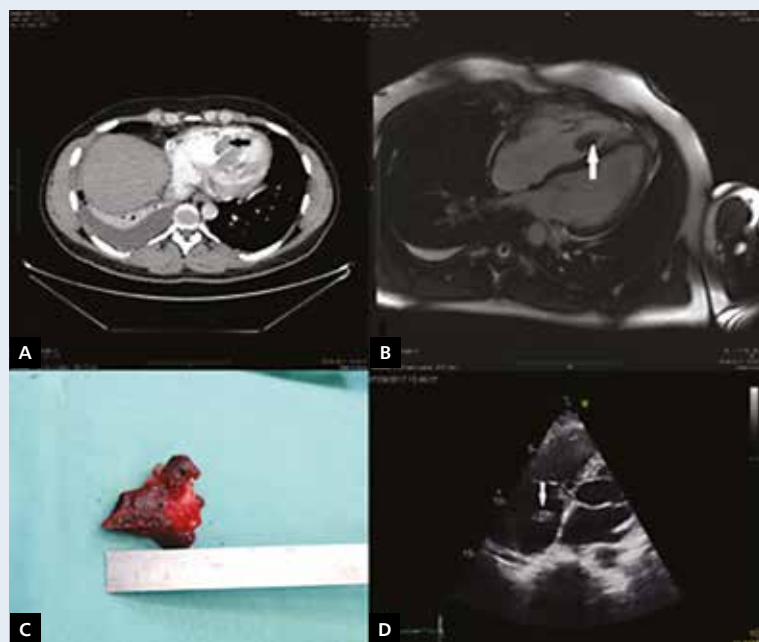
A. Tumour on computed tomography; B. Tumour on magnetic resonance imaging (arrow); C. Excised tumour covered with thrombus; D. Thrombus on echocardiography (arrow)
